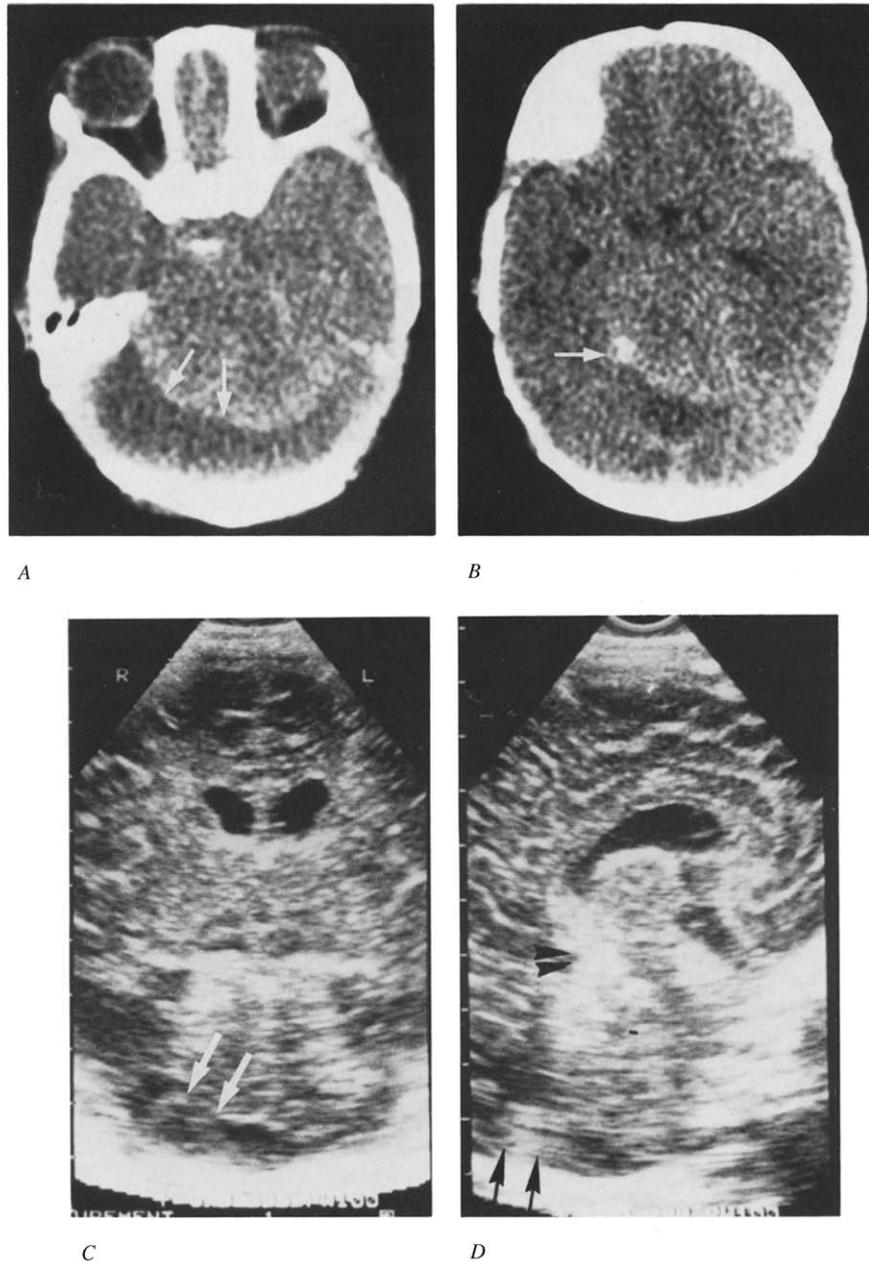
Hemorrhage over the retrocerebellar space in Patient 7. (A) At 12 days of age, CT demonstrating the retrocerebellar subdural hemorrhage (arrows). (B) CT disclosing the hemorrhage at the tentorial incisura area (arrow). (C) Coronal US documenting a mixed echogenic retrocerebellar lesion (arrows). (D) Midsagittal US revealing a retrocerebellar lesion (arrows) displacing the cerebellar vermis and an echogenic lesion at the quadrigeminal area (arrowheads).
